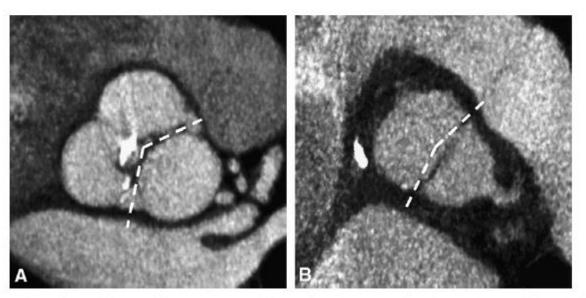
Computed tomography of an aortic root with BAV preoperatively (A) and postoperatively (B). The commissural orientation of the commissures of the nonfused cusps (dotted lines).
